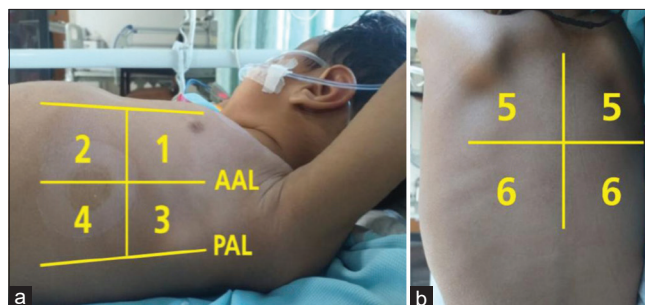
(a and b) Areas of thoracic region to be scanned by ultrasound: 1 and 2, anterior superior and anterior inferior; 3 and 4, lateral superior and lateral inferior; 5 and 6, posterior superior and posterior inferior; AAL, anterior axillary line; PAL, posterior axillary line
